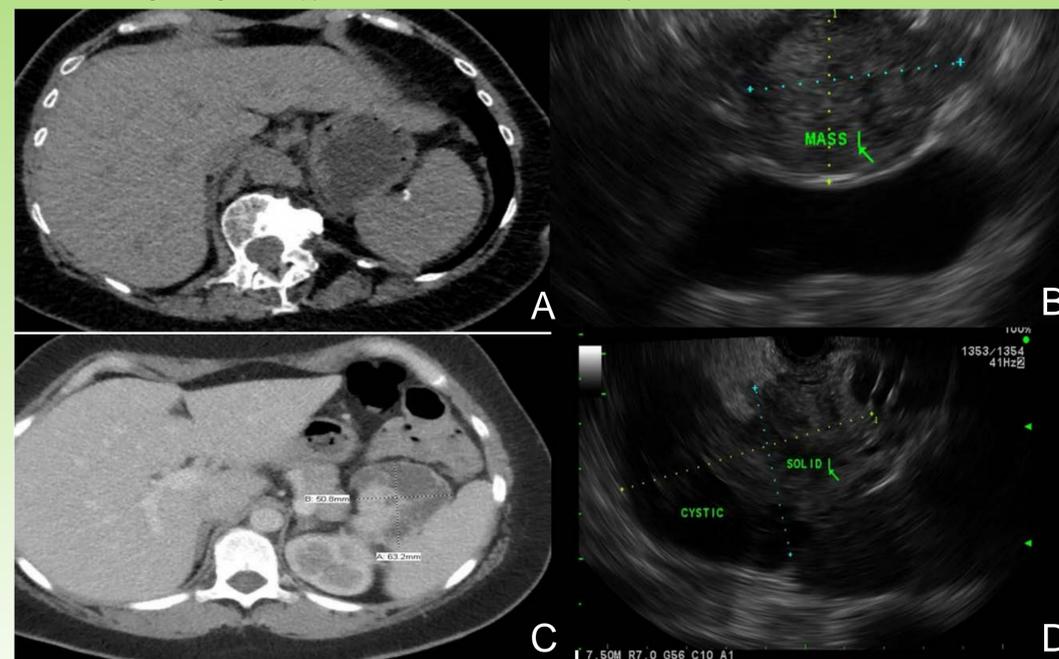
Comparing patient five's CT without evidence of PNET (A) with EUS for the same patient demonstrating a 2 cm mass in the body of the pancreas (B). We also demonstrate a large 6.5 cm PNET on CT (C) and EUS (D) for patient thirteen.
